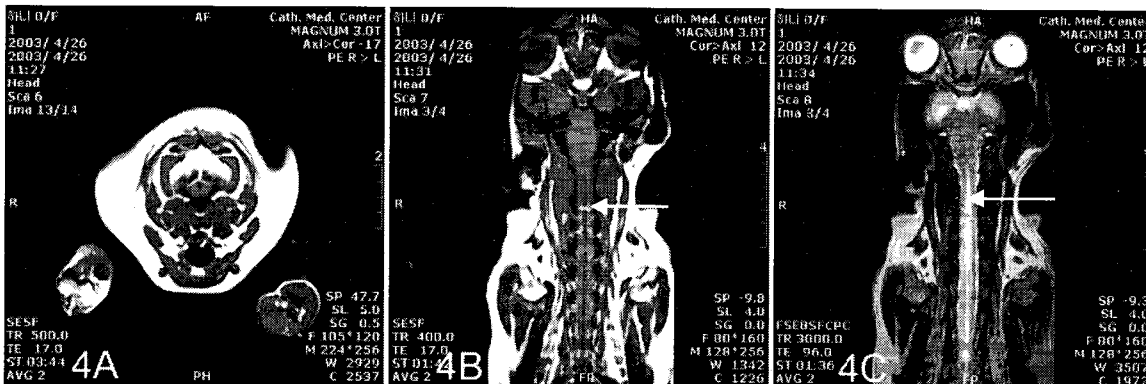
MR images of Hydrosyringomyelia. On T1 weighted transverse image (A), this lesion is noted as a small round low signal intensity in central area. T1 weighted coronal image (B) of cervical region shows well defined, long tubular, low signal intensity lesion in the central part of the spinal cord. It is seen as homogenous bright signal intensity on T2 weighted coronal image (C) (arrow). T1WI-spin echo, TR-500 msec, TE-17 msec, NEX-2, T2WI-fast spin echo, TR-3000 msec, TE-96 msec, NEX-2.
